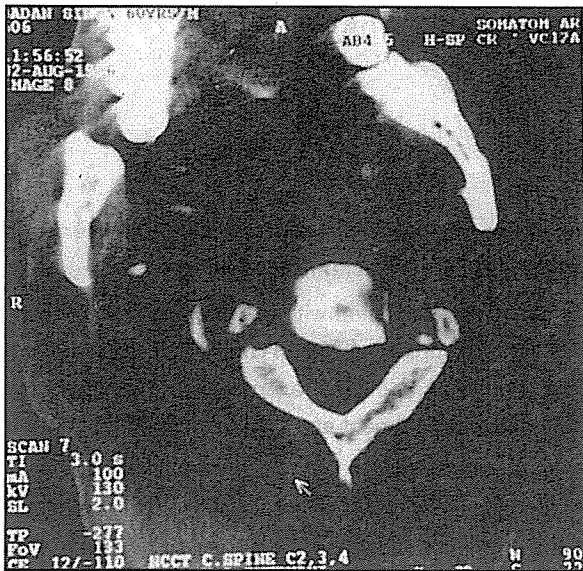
CT Scan of the cranio-cervical junction showing the destruction of first cervical vertebra following tubercular infection.
